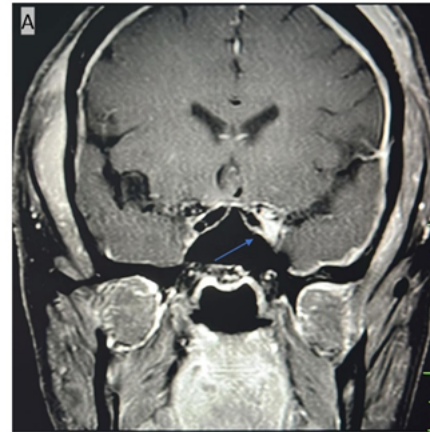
MRI of the brain with contrast revealed soft tissue thickening next to left cavernous sinus and left orbital apex with contrast enhancement (blue arrow), along with diffuse pachymeningitis.
